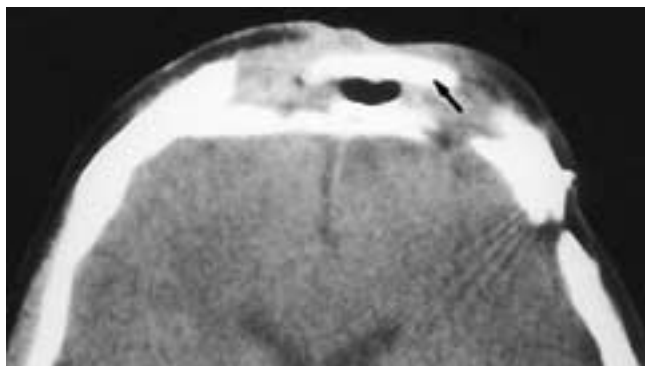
Axial CT scan shows an infected osteoplastic flap. There is swelling of the overlying forehead soft tissues, and the bone flap (*arrow*) has been partially eroded. In addition, just behind the flap there is air, which should not be present in an obliterated sinus. The defect in the left posterior sinus table was related to the surgery.
